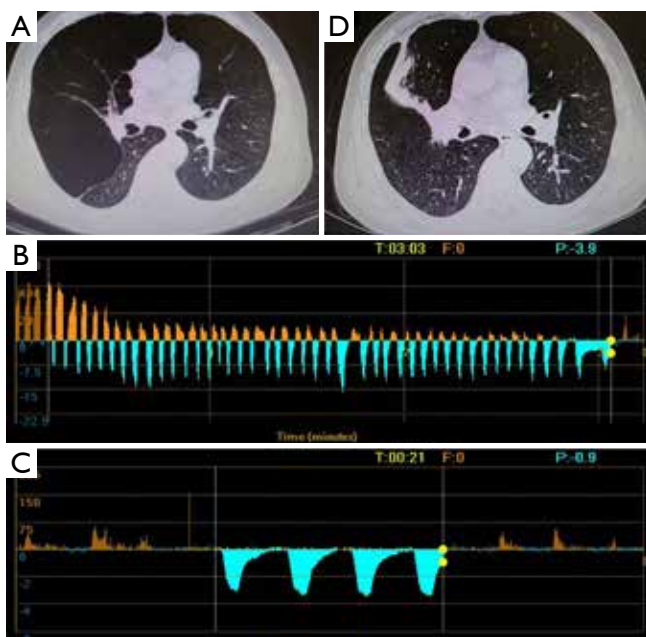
Chest CT and Chartis result of patient 1. (A) A bulla in the RLL and atelectasis of right RML; (B) drop of airflow to zero indicated CV is negative at RUL; (C) Chartis test showed low flow at RML; (D) Chartis test showed low flow at RLL; (E) the volume of bulla reduced and the atelectasis of RML disappeared. RLL, right lower lobe; RML, right middle lobe; CV, collateral ventilation; RUL, right upper lobe.
